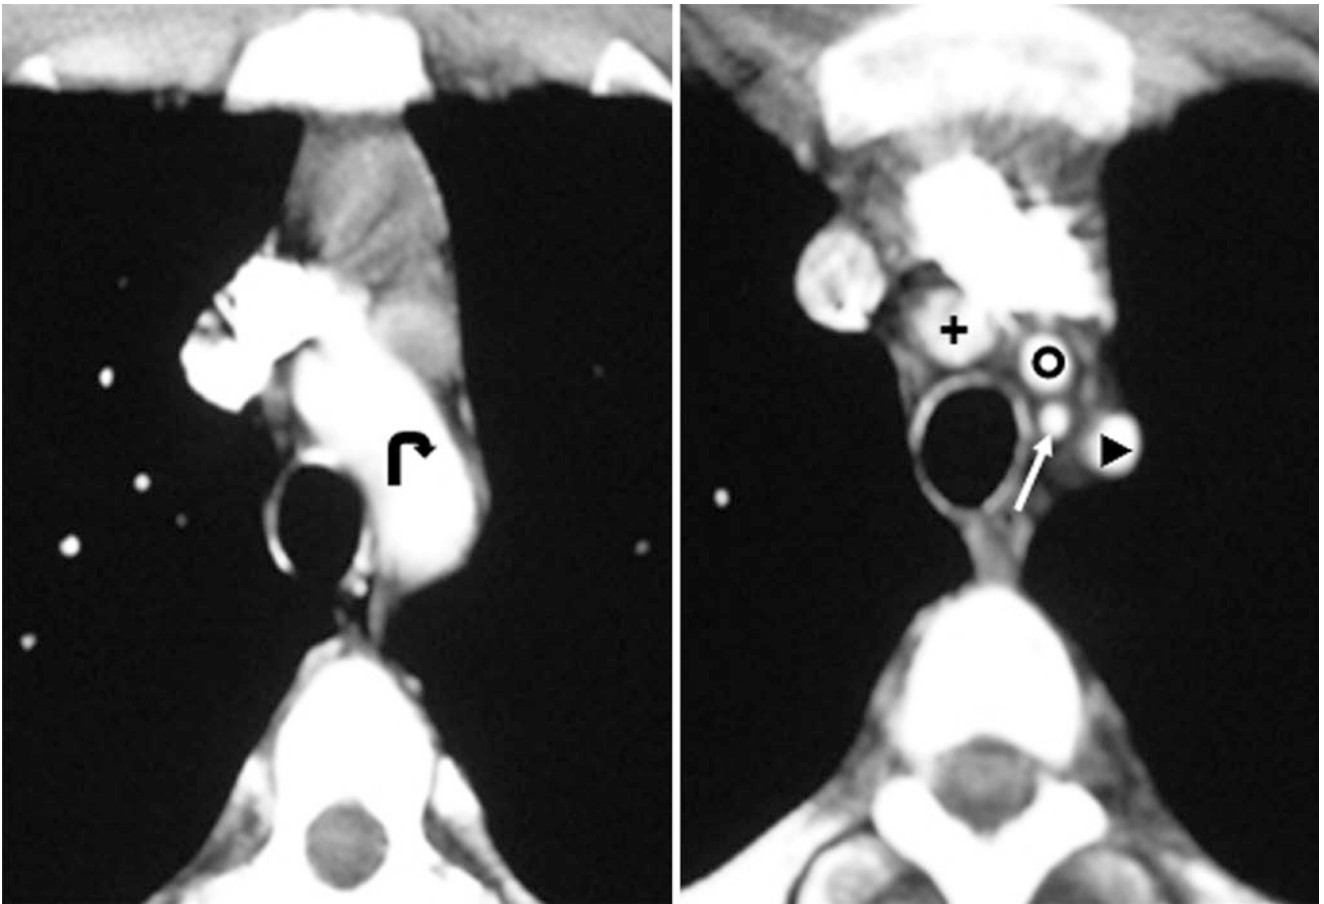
33-year-old with the typical configuration of an “arch origin” of the LVA (*arrows*) on axial contrast-enhanced CT images at the level of the top of the arch. *Aortic Arch* (*curved arrows*); *IA* Innominate
